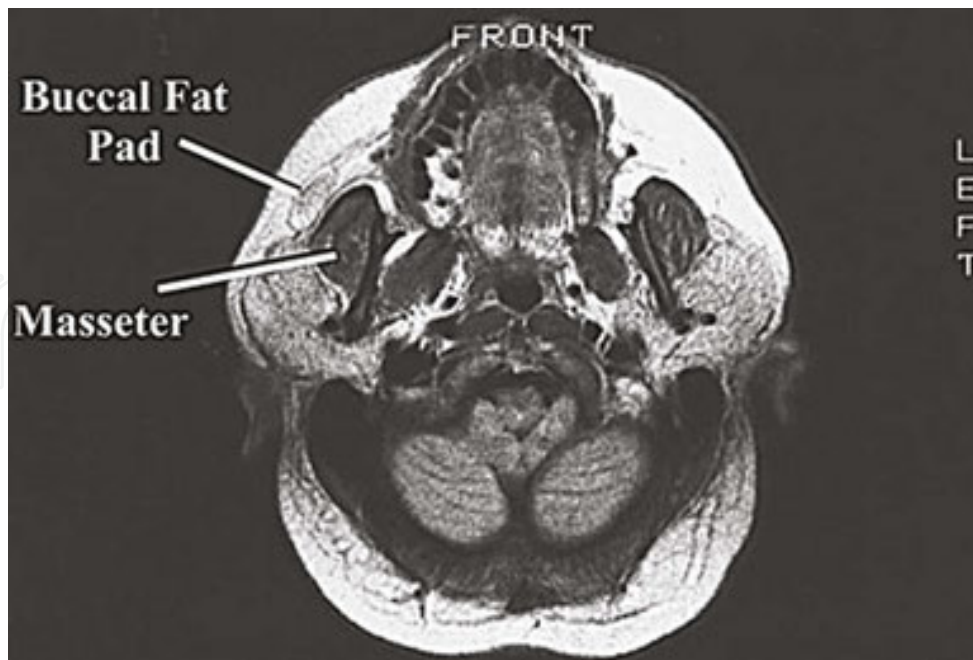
Cross-section of T1 MRI at the level of the oral cavity and the hard palate. The BFP is evident anteriorly to the masseter. Notice the volume of the BFP in relationship to the masseter (Yousuf et al. [28]).
